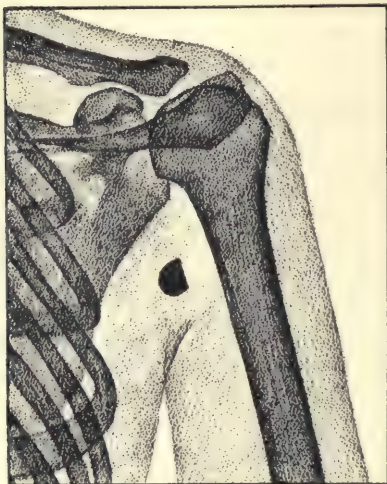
The same radiograph of the right shoulder seen from back. We now have a positive and the image is still presented as in the two foregoing figures. We observe the slightly deformed shrapnel bullet in the inner front part of the axilla. Its position on the radiograph enables us to affirm that it is *extra-thoracic* and lodged in the *soft parts*.
